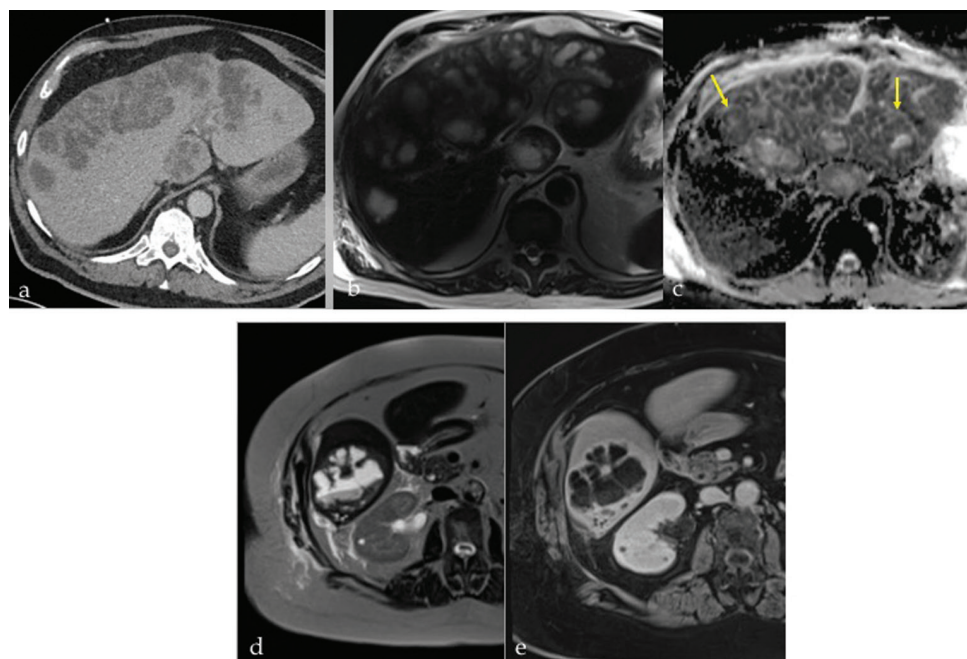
Pyogenic abscesses. Multiple liver abscesses on (a) computed tomography, (b) T2W magnetic resonance imaging and (c) apparent diffusion coefficient map. These are seen as septated cystic lesions with internal restriction of diffusion (arrows). Another case of liver abscess on (a) T2W and (b) T1W post contrast images, showing multiple enhancing septations.
